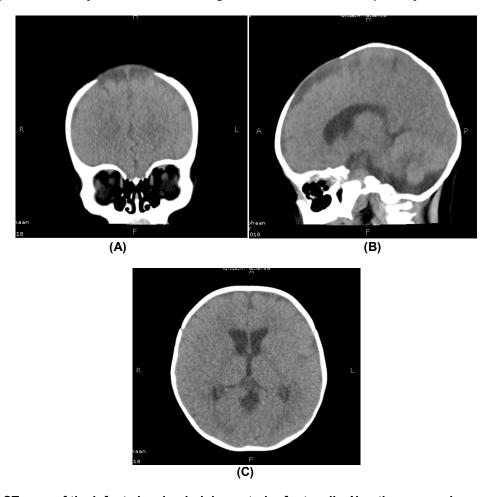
CT scan of the infant showing bulging anterior fontanelle. No other gross abnormality is identified. (A) Coronal view. (B) Sagittal view (C) Axial view with normal lateral and third ventricles, no evidence of raised intracranial pressure
